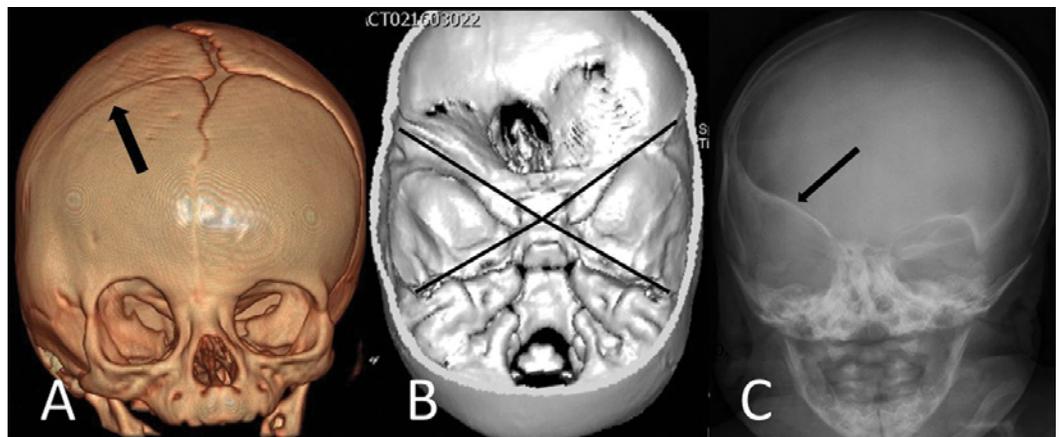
A 3D-reconstruction shows the prematurely fused right coronary suture (arrow) and the deformation of the skull base (B). On X-rays, a typical Harlequin deformity (arrow) caused by superior displacement of the large sphenoid wing can be seen (C).
